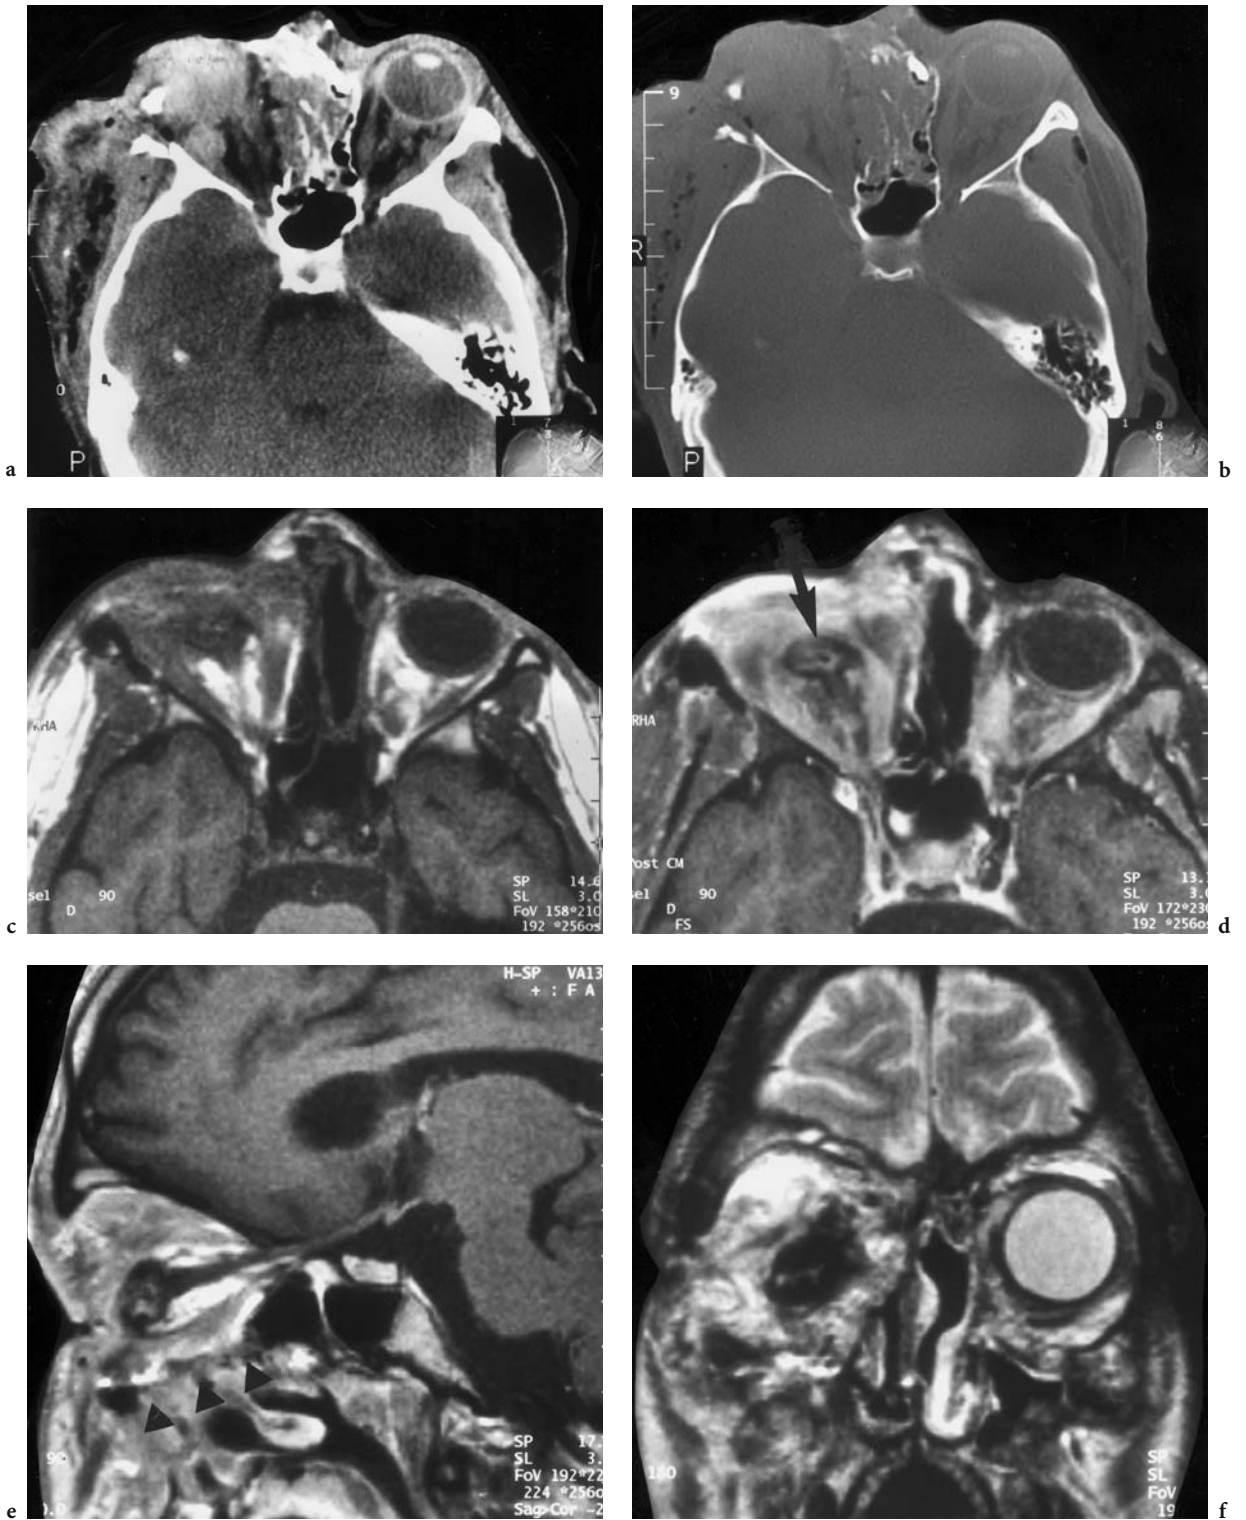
A 19-year-old male car accident victim (no seat belts worn at the time of the accident). At follow-up (6 months after accident), the patient presented with suspicion of endophthalmitis. Diagnosis: right globe rupture with vitreous body hemorrhage, multiple orbital wall fractures, developing posttraumatic phthisis. Axial CT: a Multiple fractures of all orbital walls with penetrating fragment into the globe, vitreous hemorrhage, and post-bulbar hematoma. b Corresponding bone window. MR (carried out 6 months later): c axial T1-weighted view with small, shrunken right bulb in the inferior orbit and dislocation of the medial external muscle into the fractured ethmoidal sinus. d Corresponding contrast-enhanced (FS) view with enhancement of fibrous scar tissue as intense as enhancement of the external muscles. Note signal enhancement of the residual choroid (*arrow*). e Parasagittal, T1-weighted, contrast-enhanced (FS) view, showing the integrity of the optic nerve, although differentiation of the external muscles from scars in the area is difficult. Note the irregularity of the orbital floor (*arrowheads*). f Coronal T2-weighted image, demonstrating posttraumatic enlargement of the entire right orbit and hyperintensity of the scars in the vicinity of the shrunken globe
